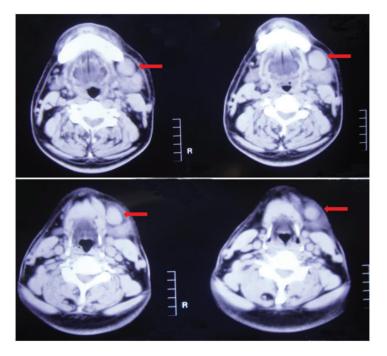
Plain computed tomography of the neck.
